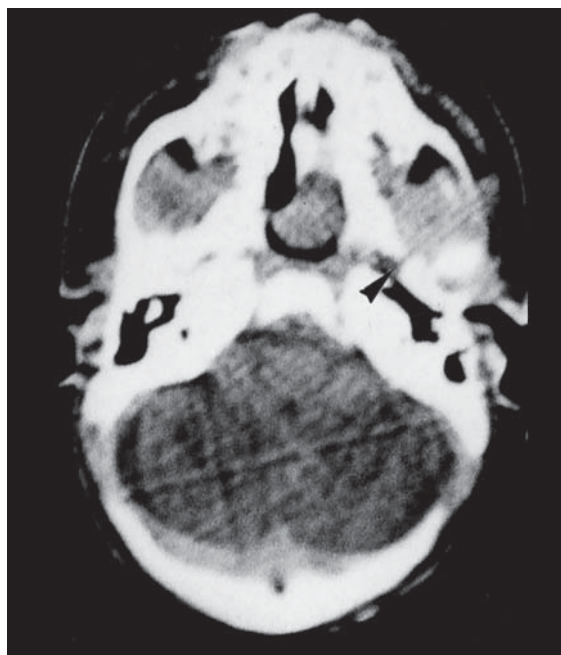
Case 1. CT without enhancement, axial view. A mass is noted in the nasopharyngeal region without bony defect at the base of the anterior cranial fossa or the sellar floor, demonstrating a 2 mm slit over the sphenoid bone (arrowhead).
